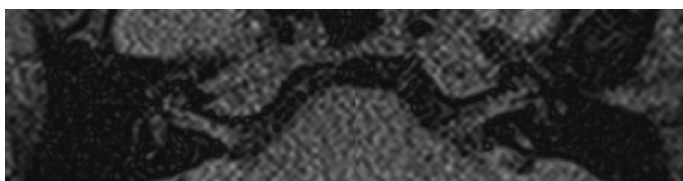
Picture of the inner ear and middle ear before gadolinium enhancement in case 2 3D-FLAIR sequence.
